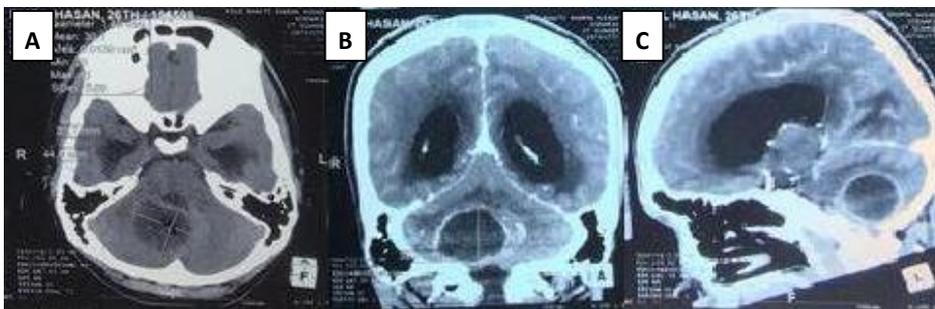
Axial view of head CT-scan without contrast (A) revealed the cystic lesion in the right cerebellar hemisphere and with contrast (B) revealed a ring-enhancing mass in the right cerebellar hemisphere. Sagittal view of head CT-scan with contrast (C) revealed the ring-enhancing mass was located in the infratentorial region of the brain.
